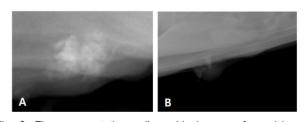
The representative radiographic images of suspicious morphology in mammary gland tumors. Coarse heterogeneous (A), and fine pleomorphic (B) calcification.
